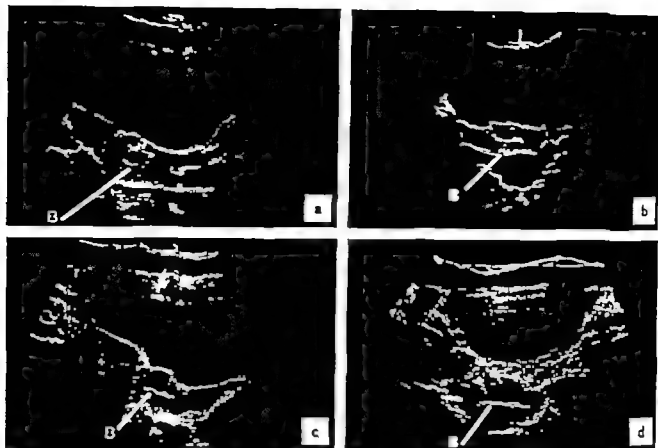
a, b c and d. The sonogram of the steel band (B) in a longitudinal section of the uterus (a and c), and in transverse section (b and d).
